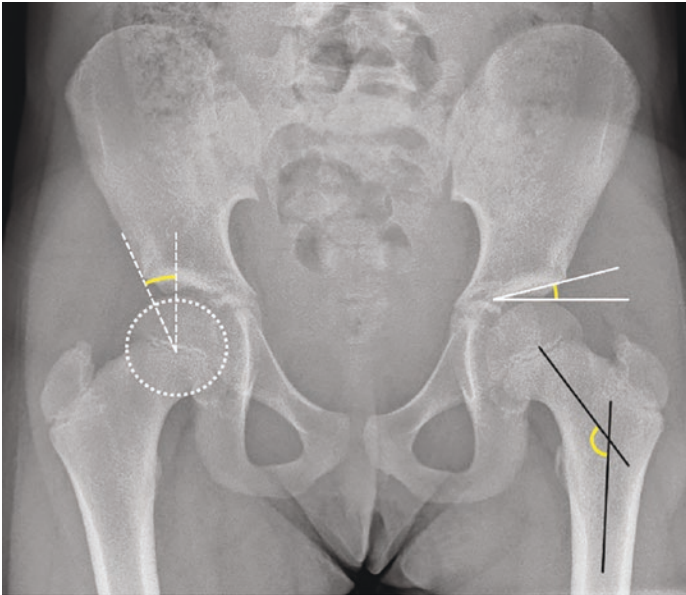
Anteroposterior radiograph showing the lateral center-edge angle (Wiberg) (dashed white lines), Tönnis angle (bold white lines), and femoral head-neck-shaft angle (bold black lines)
